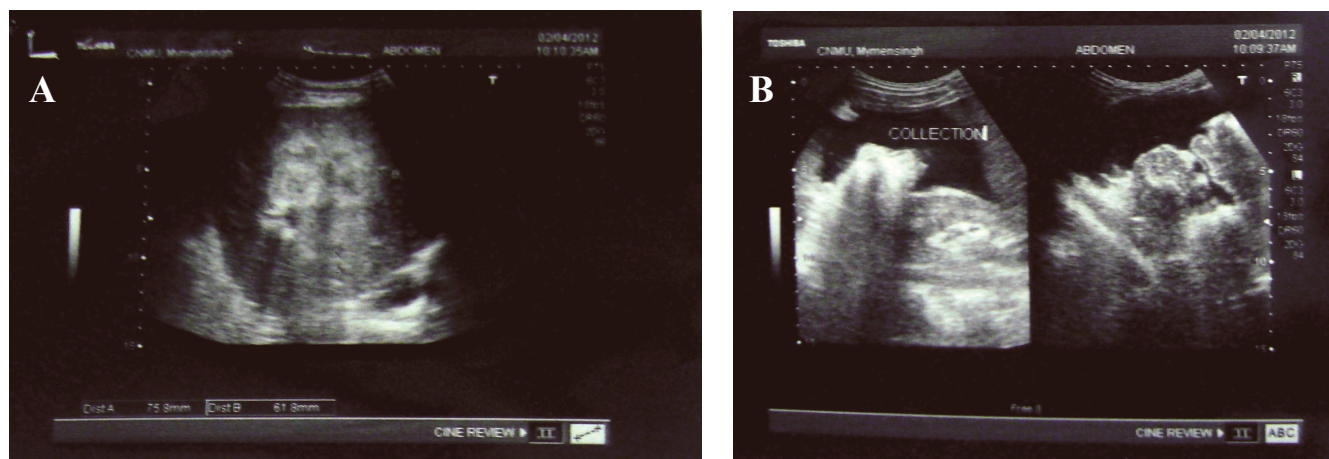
(A) Image of 25 years man admitted to hospital after a motor vehicle accident transverse images of ultrasound shows an area of laceration in right lobe of liver and (B) hemorrhagic collection in peritoneal cavity.
